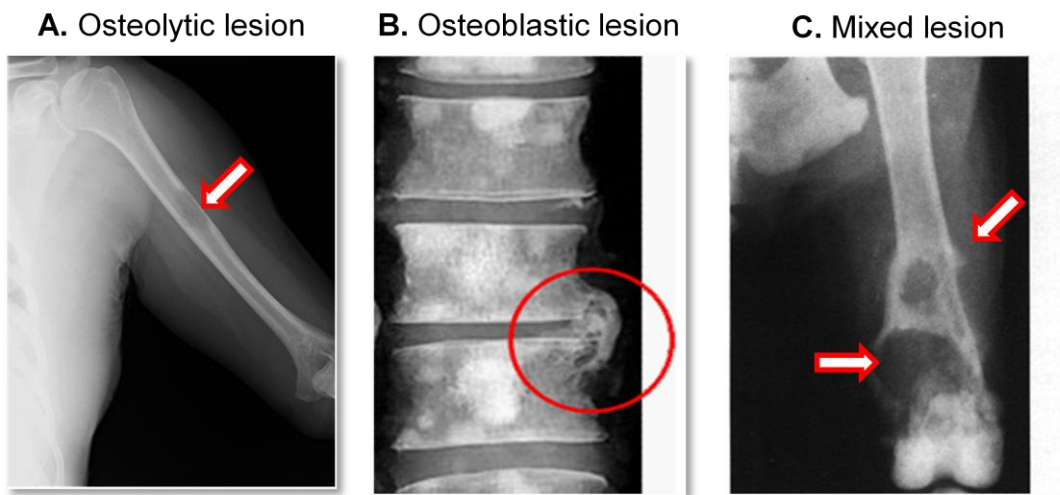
Radiographic representation of morphological features of cancer-induced bone destruction.
